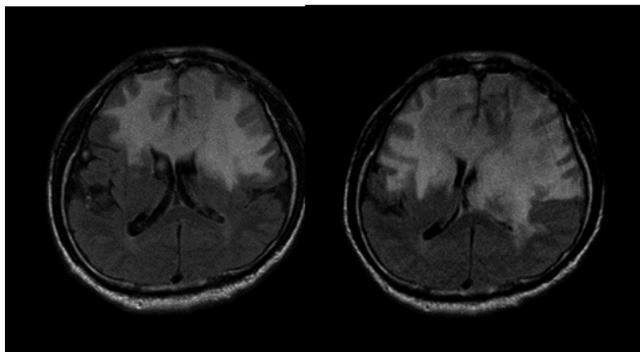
Fluid attenuated inversion recovery (FLAIR) MRI image
